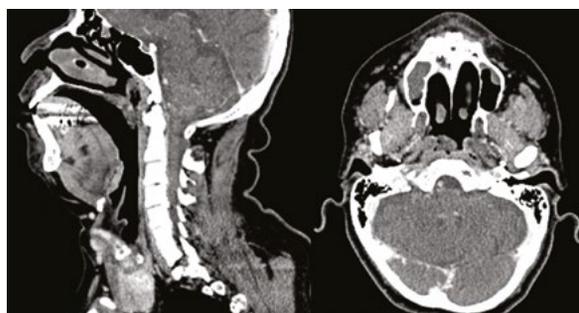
Computed tomography of the neck revealing non-enhancing nasopharyngeal soft tissue lesion
